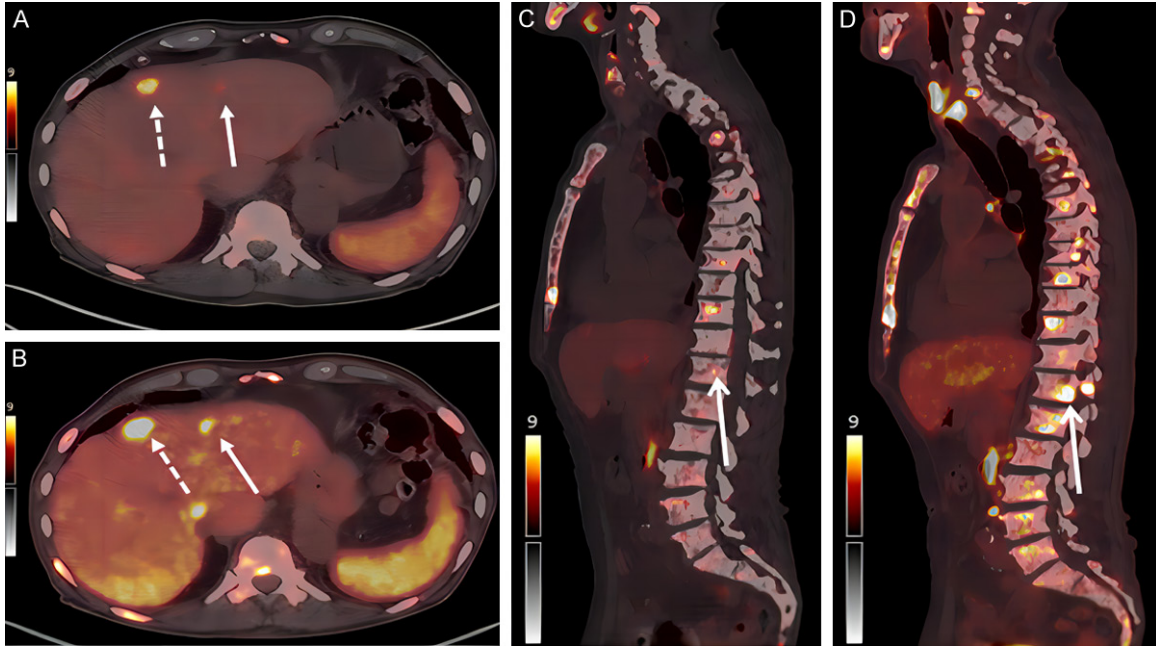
(A, C) show ^{68}Ga -PSMA-11 PET/CT and (B, D) show additional PET/CT performed 1 h after additional FDG administration. Images reprinted from [52] with permission.
